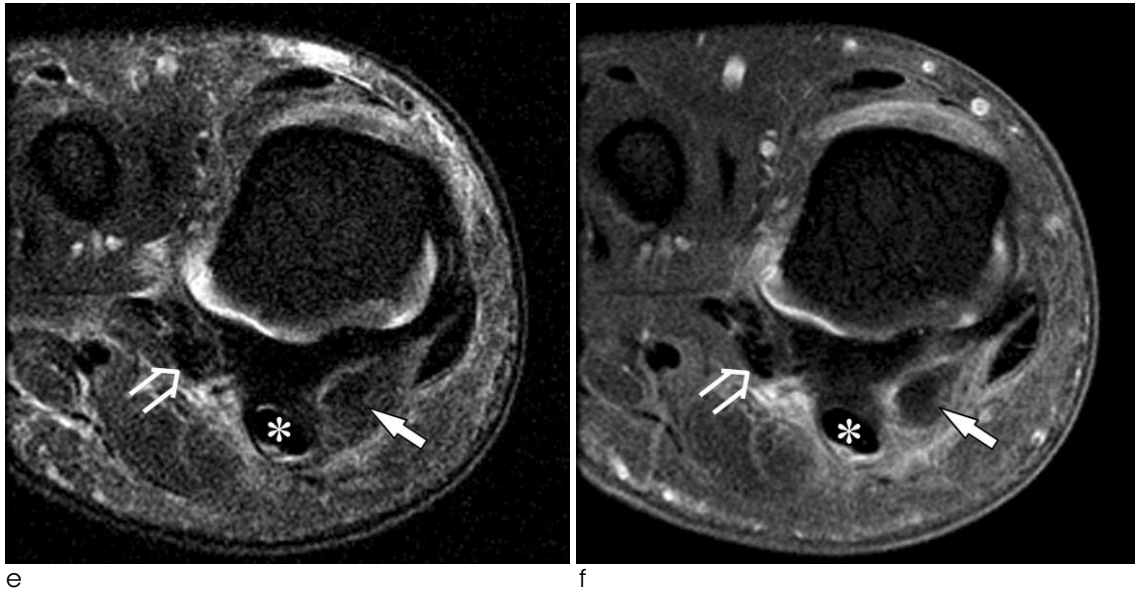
Coronal fat-suppressed T2-weighted (e) and contrast-enhanced fat-suppressed T1-weighted (f) images show diffuse soft tissue edema and enhancement around the calcification (arrow) in the medial head of flexor hallucis brevis tendon. The flexor hallucis longus (asterisk) and lateral head of flexor hallucis brevis (open arrow) tendons are indicated. ms = medial sesamoid.
